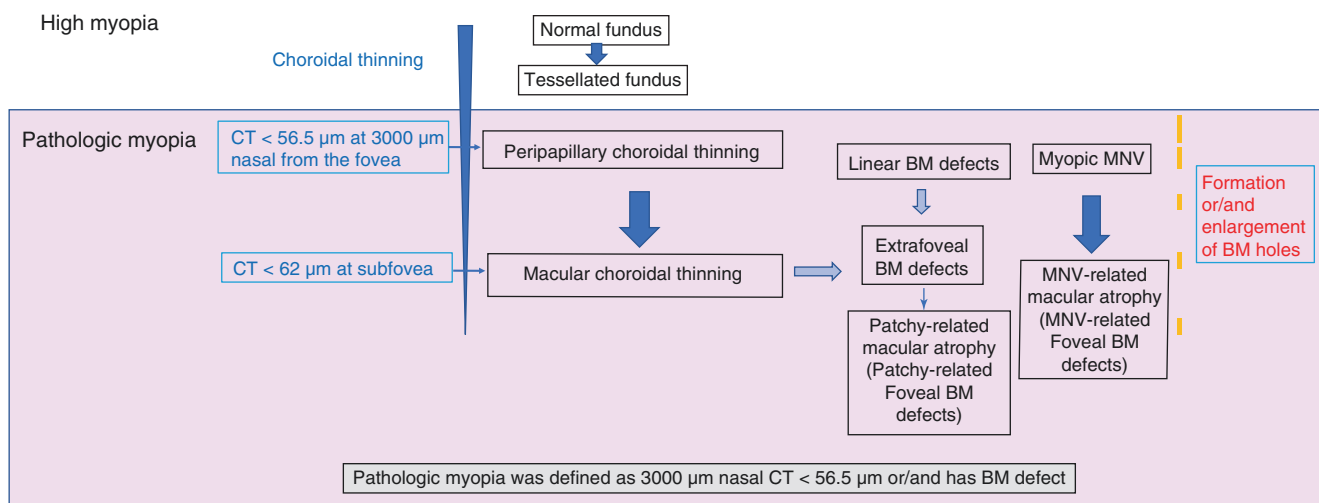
A scheme depicting the progression patterns of myopic maculopathy and corresponding characteristics of OCT findings. *BM* Bruch's membrane, *MNV* macular neovascularization, *CT* choroidal thickness
